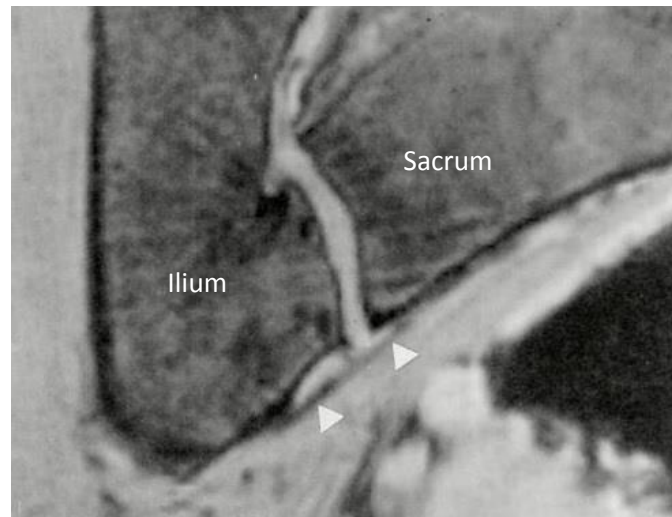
A 3D reconstructed coronal section MRI of the anterior sacroiliac ligament (arrowheads) traversing the sacroiliac joint (taken from Jaovisidha *et al*, 1996).
